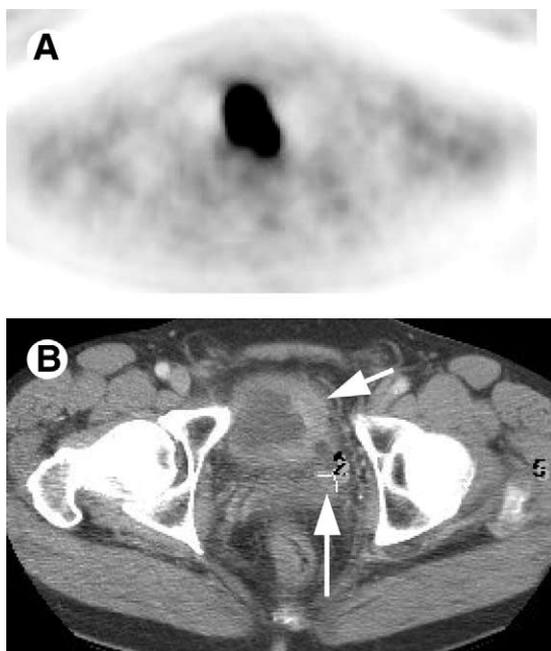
Bladder cancer imaging with FDG. (A) Transaxial FDG-PET image shows excreted tracer in the urinary bladder. (B) The corresponding CT image shows thickening of the bladder wall and a 1.7×1.3 cm left perivesical lymph node, likely metastatic. On PET, however, the tumor cannot be identified because of accumulation of excreted tracer in the bladder. FDG is not a suitable tracer for the staging of bladder cancer.
